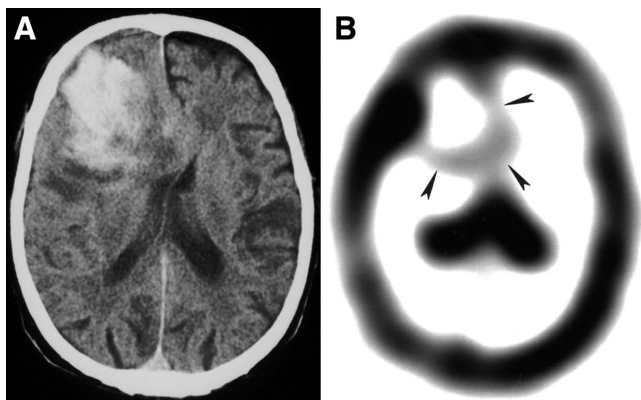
Patient 19, a 71-y-old man with sudden onset of left-sided hemiparesis and drowsiness. (A) Emergency CT scan shows atypically located 5-cm large, inhomogeneous hematoma in right frontal region. Lesion is surrounded by moderate edema and determines compression of lateral ventricles and subfalcine herniation. (B) ^{99m}Tc -MIBI SPECT image obtained at 10 d shows ringlike ^{99m}Tc -MIBI uptake at periphery of lesion (arrowheads) (^{99m}Tc -MIBI index = 1.9).
